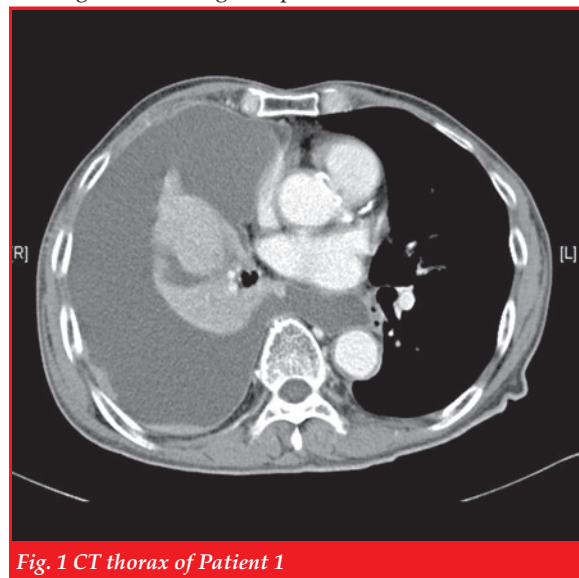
CT thorax of Patient 1
